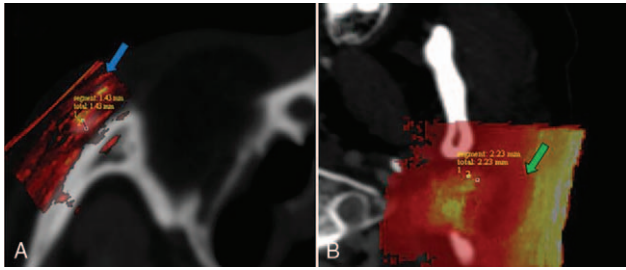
A display of the CT and ultrasound fusion image. (A) A CT and ultrasound fusion image of a foreign body; the blue arrow indicates the superimposed display area of the 2 images. (B) A CT and ultrasound fusion image of a parotid mass; the green arrow shows the superimposed display area for the parotid mass. CT, computed tomography.
